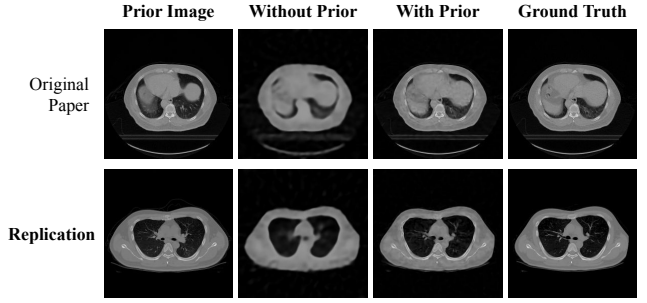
Results of 2-D CT image reconstruction in the original paper and replication with COVID lung CT data using 20 projections.
